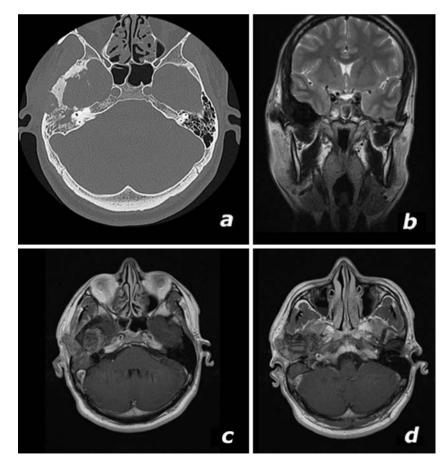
Neuroradiology. Axial CT demonstrates a mixed lytic and sclerotic lesion of the right middle cranial fossa (a). Coronal T2-weighted (b) MRI scans show the lesion to be of low signal and axial post gadolinium T1-weighted images show it undergoes heterogeneous gadolinium enhancement (c, d)
